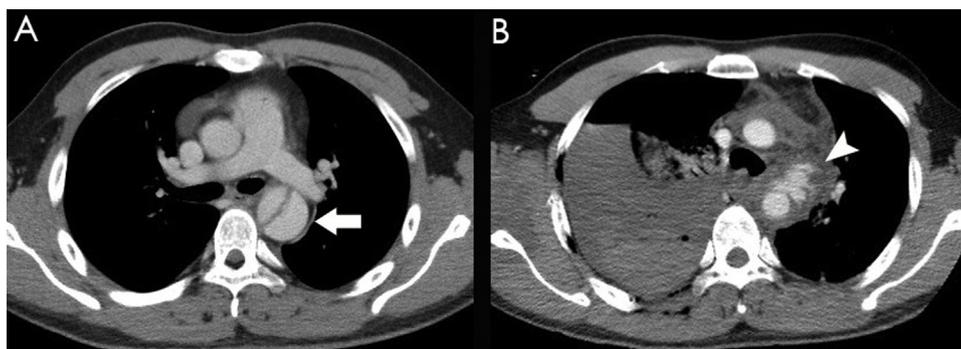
Axial view of a computed tomography scan of aortic trauma. (A) An aortic injury with intimal flap and dissection (arrow). (B) An aortic injury with extravasation (arrowhead) and predominant right hemothorax.
